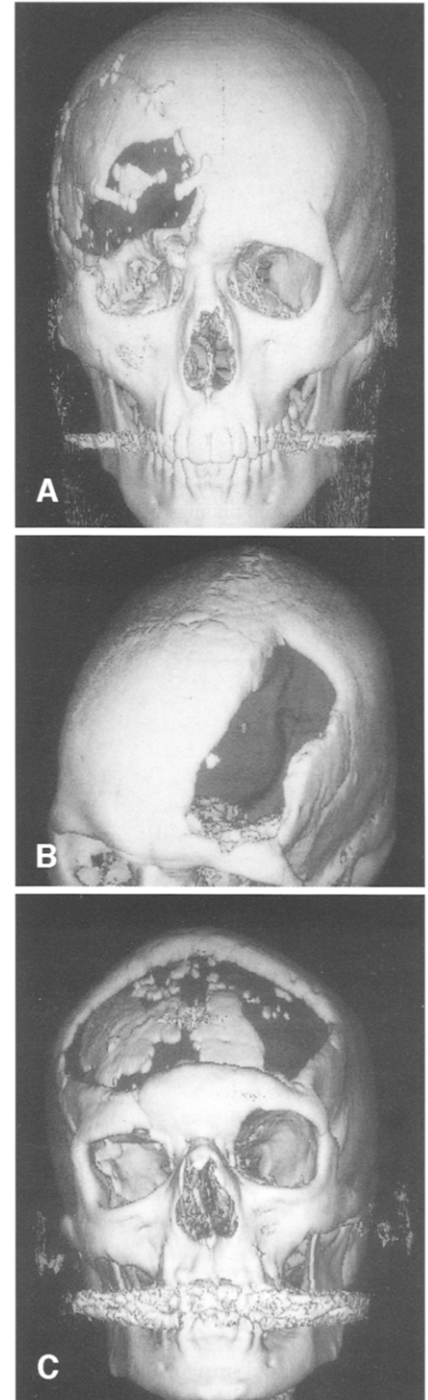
A–C) Initial 3D-CT of patients A–C.
